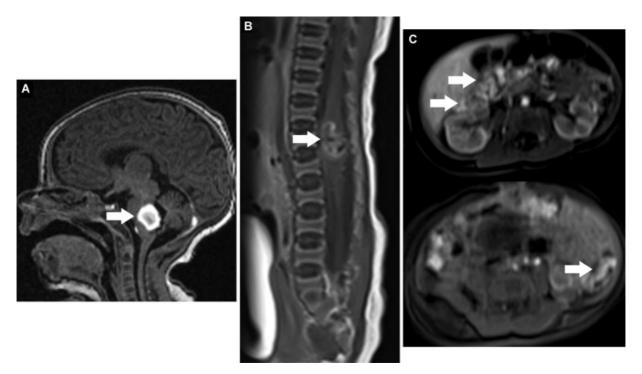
Initial MRI findings on admission. (A) T1 sagittal MRI without contrast demonstrates hyperintense hemorrhagic focus in the midbrain (arrow). (B) T1 post gadolinium with peripherally enhancing hypointense focus in the distal spinal cord (arrow). (C) T1 post contrast arterial enhancing serpiginous structures in the hepatorenal space (arrows) and associated with the descending colon (arrow). MRI, magnetic resonance imaging.
